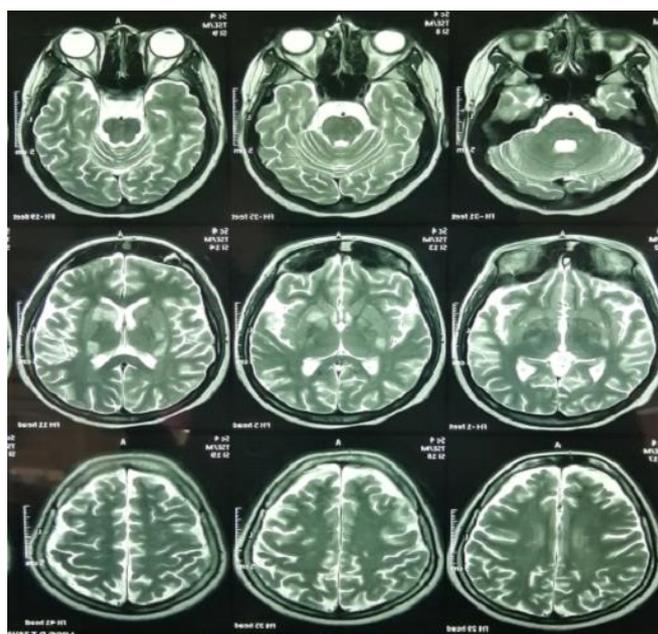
T2 weighted MRI showing bilateral asymmetrical hyperintense enhancements distributed in supratentorial regions of the brain which is compatible with radiographic evidence of ADEM like CNS lesions
